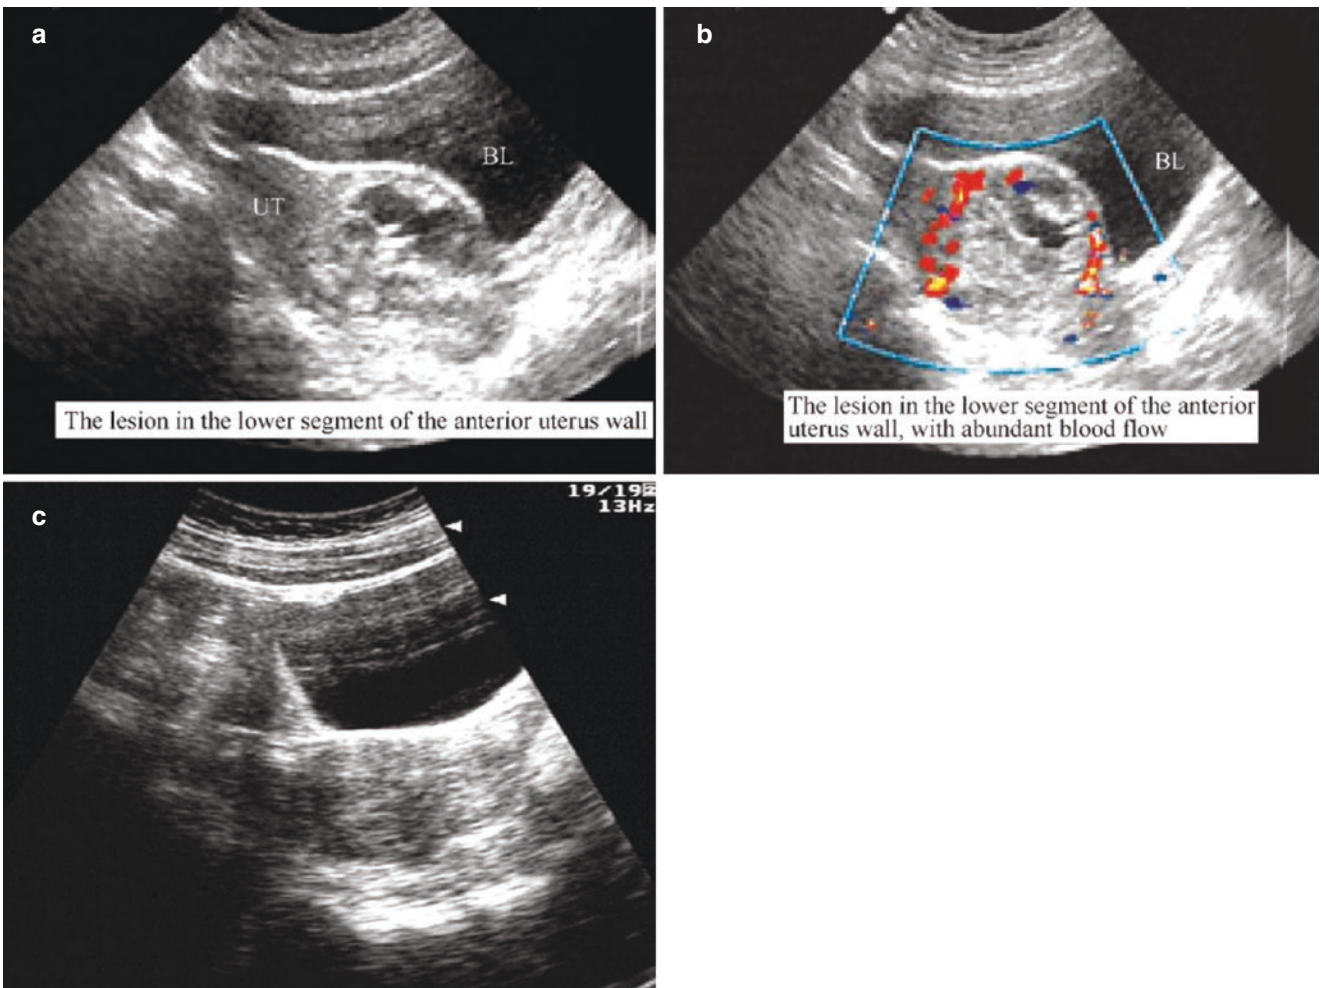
Identification of incomplete abortion. (a, b). The cesarean scar pregnancy is misdiagnosed as incomplete abortion. After several times of curettage, serum hCG was positive. Via ultrasound examination, the lesion in the lower segment of the anterior uterus wall is visible, with abundant blood flow. After clinical conservative treatment, hCG decreased; (c). The cesarean scar pregnancy is cured after treatment
